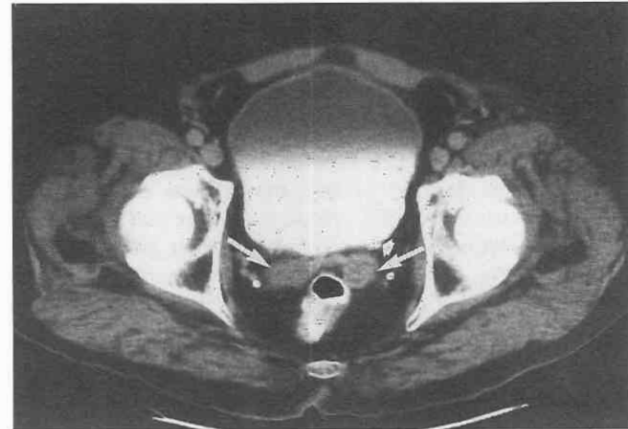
Normal anatomy. CT scan shows the seminal vesicles (*arrows*) between the bladder and rectum and the left pelvic ureter entering the bladder (*arrowhead*).
